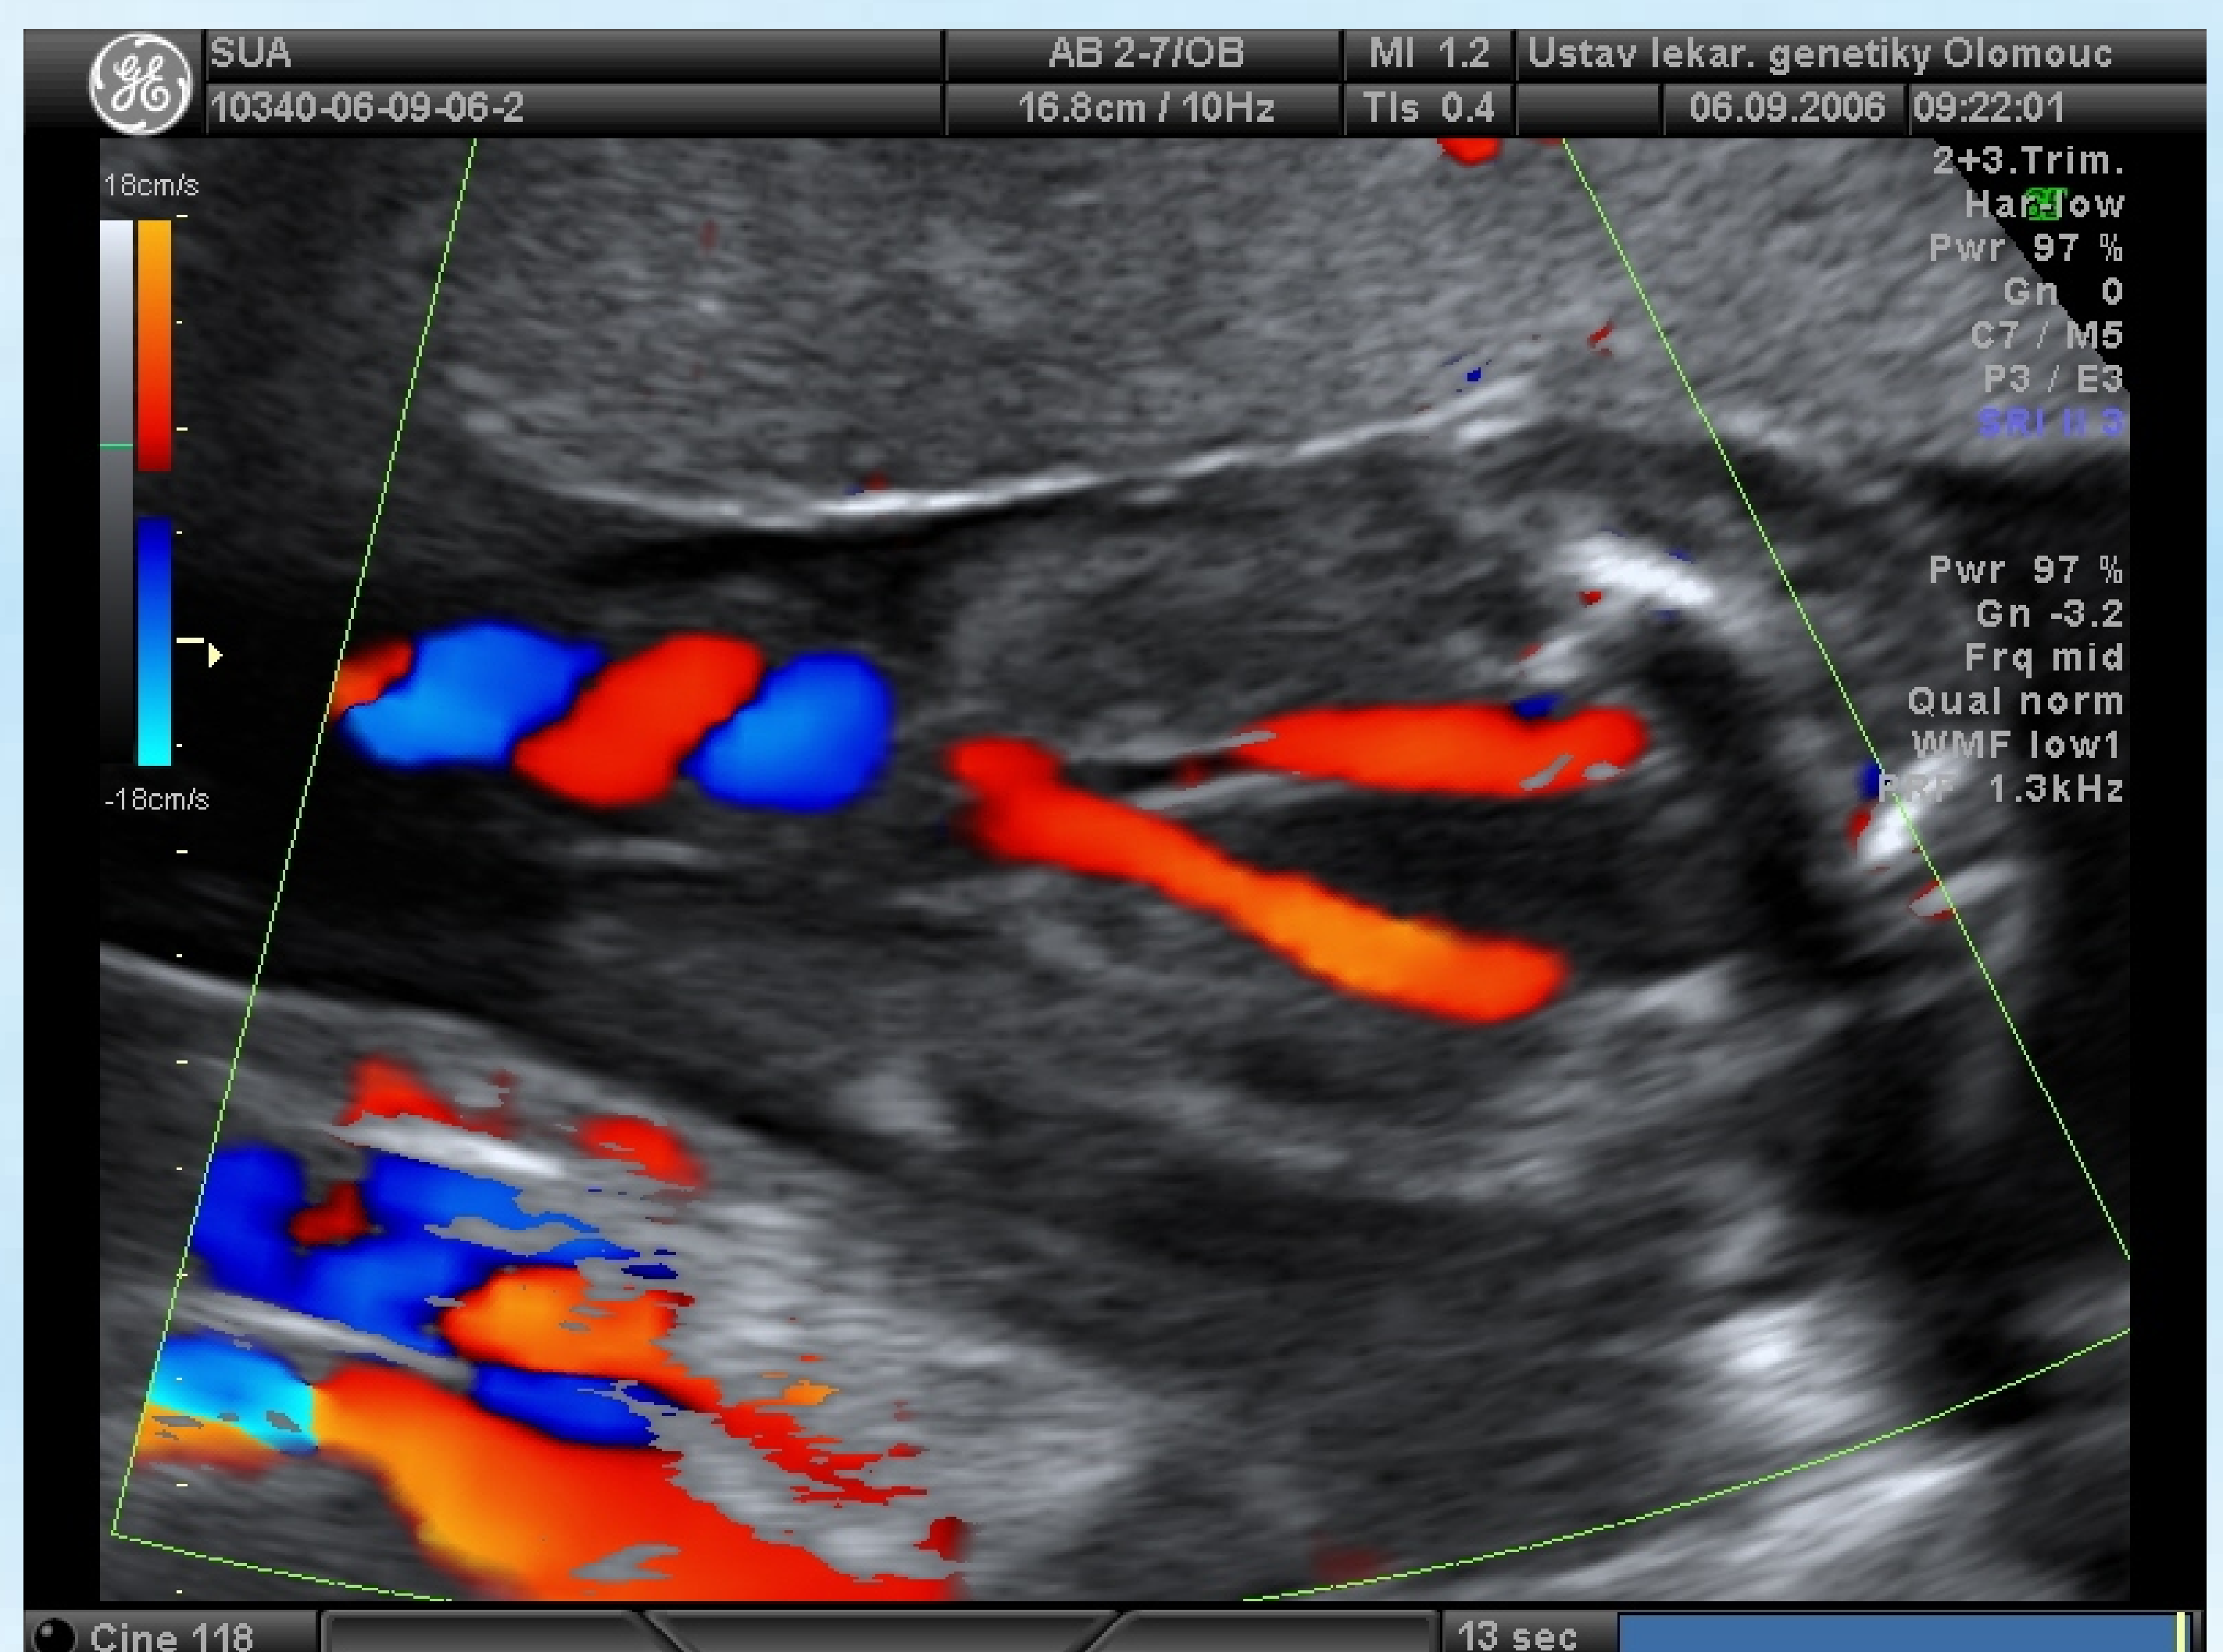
Transverse view of fetal pelvis, which color flow Doppler showing umbilical arteries as they course around the bladder
